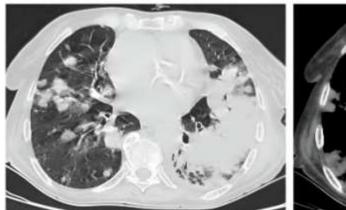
(AB):- CT scan in axial sections, parenchymal and mediastinal window showing left lower lobar pulmonary lesional process with multiple bilateral confluent intra-parenchymal nodules (blue arrow).
